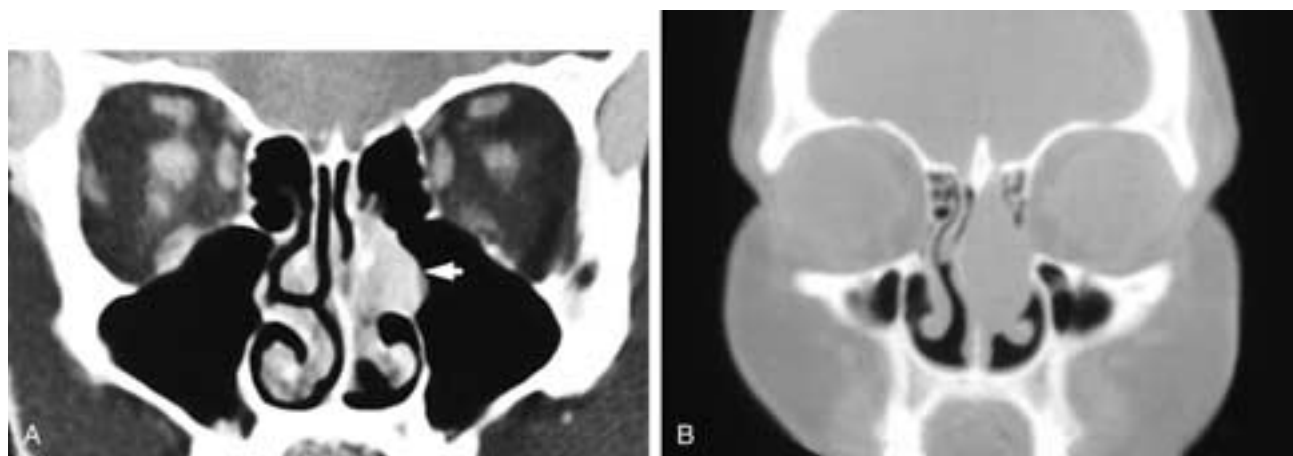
A, Coronal CT scan shows a small polypoid mass in the left nasal fossa (arrow) obliterating the middle meatus. There is no associated bone destruction. This patient had an inverted papilloma. B, Coronal CT scan on another patient shows an expansile left nasal fossa polypoid mass that bows the nasal septum to the right. There is no gross bone erosion. This patient had an inverted papilloma.
